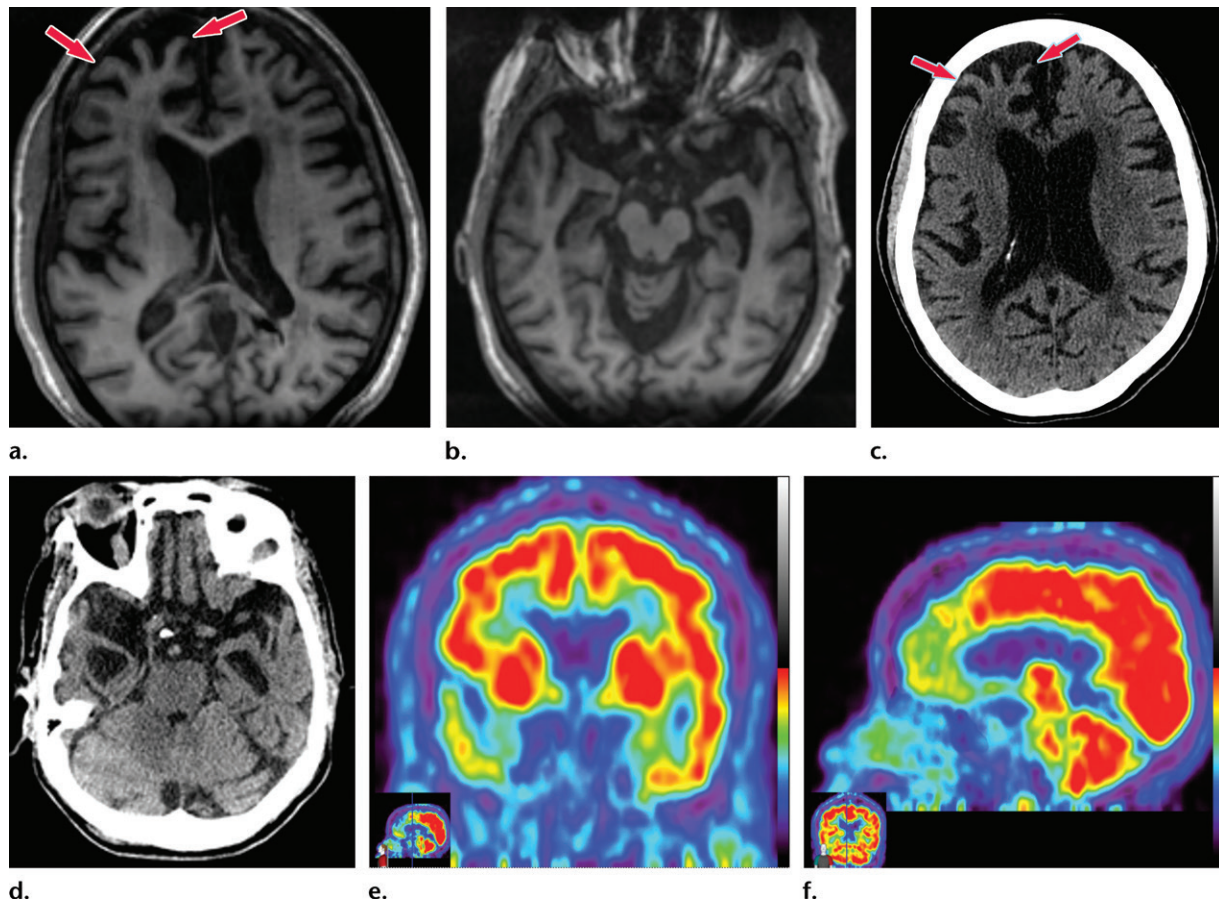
Frontotemporal lobar degeneration. (a, b) Axial T1-weighted MR images at the convexities (a) and temporal lobes (b) show moderate frontotemporal atrophy. Note the atrophy at the right frontal lobe (arrows in a). (c) Follow-up axial CT image at the lateral ventricles obtained 5 years later shows asymmetric worsening atrophy (arrows) on the right. (d) Axial CT image shows similar asymmetric worsening at the temporal lobes. (e, f) Coronal (e) and sagittal (f) ^{18}F -FDG PET images obtained on the same day as the CT images show corresponding decreased activity in the frontal and temporal regions, findings compatible with FTLD. Image insets show a coronal section through the middle of the brain in this particular case to aid in lateralization.
